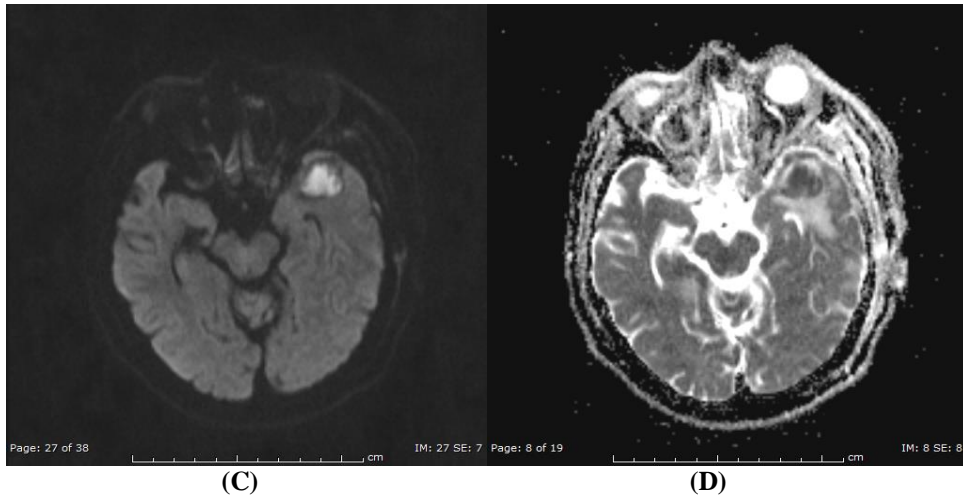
A case of STAGE III RCM with fungal abscess , a-axial Post contrast T1FS image showing peripherally enhancing lesion in the left anterior temporal lobe, which on SWI (Image-b) showing peripheral blooming and on DWI and ADC (c,d) showing peripheral restriction
